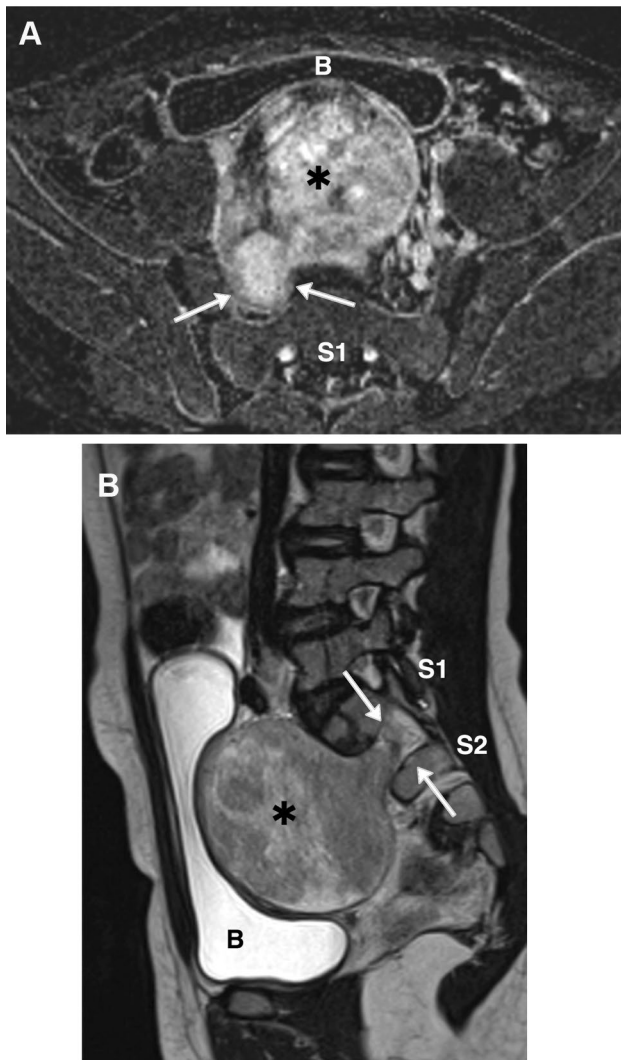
A Ganglioneuroma in a young female. b Axial subtraction T1W FS image demonstrates a large (5×7 cm) heterogeneously enhancing, well-circumscribed pelvic, midline mass (asterisk). The mass extends/arises from the widened right S1-2 neural foramen (arrows). The mass abuts the right ovary and right iliac artery but it does not encase the vasculature and there is no evidence of right ovarian involvement (not shown, B=urinary bladder) b Sagittal T2-weighted image reveals heterogeneous hyperintensity signal within the mass. Note mass effect on the adjacent posterior wall of the urinary bladder (b). Again appreciated is the extension on the mass into the right S1-2 neural foramen (white arrows) B Ganglioneuroma in a young female. a Axial subtraction T1W FS image demonstrates a large (5×7 cm) heterogeneously enhancing, well-circumscribed pelvic, midline mass (asterisk). The mass extends/arises from the widened right S1-2 neural foramen (arrows). The mass abuts the right ovary and right iliac artery but it does not encase the vasculature and there is no evidence of right ovarian involvement (not shown, B=urinary bladder) b Sagittal T2-weighted image reveals heterogeneous hyperintensity signal within the mass. Note mass effect on the adjacent posterior wall of the urinary bladder (b). Again appreciated is the extension on the mass into the right S1-2 neural foramen (white arrows)
